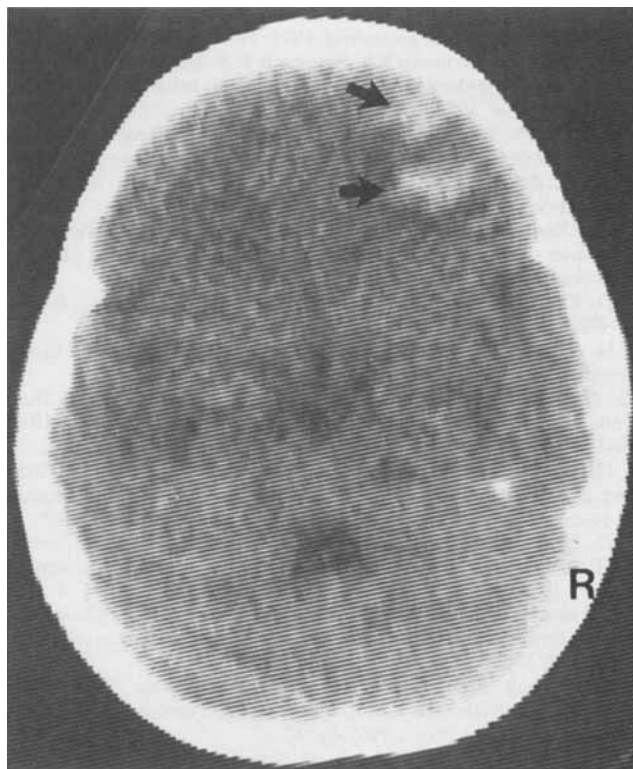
Case 3. Unenhanced CT scan showing two areas of hemorrhaging in the right frontal lobe (arrows). The presence of two separate areas of hemorrhaging suggests that hemorrhagic infarction may be present.
